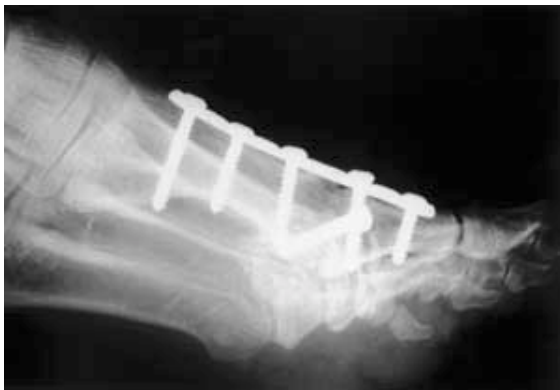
Postoperative radiograph of arthrodesis with dorsal plate fixation. b) lateral radiograph.
